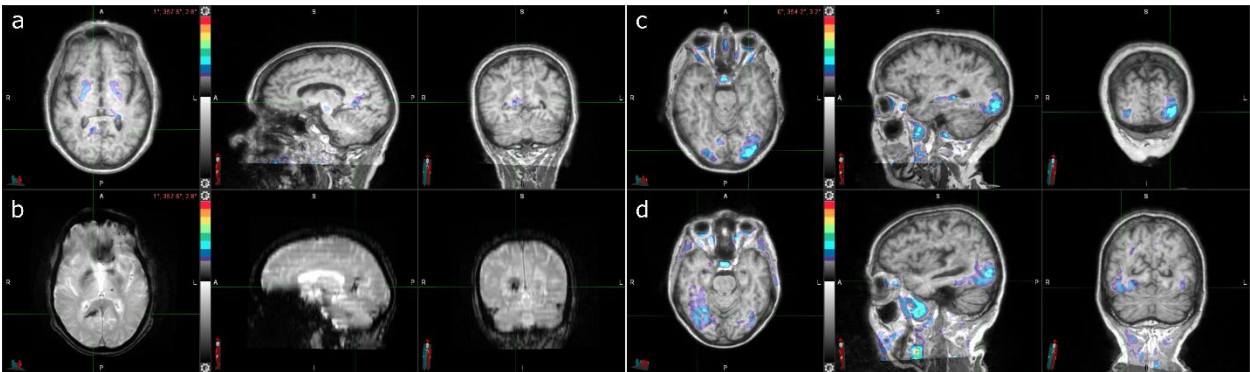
Three cases with tau-positive visual interpretations, but tau-negative SUVRs. (a) Tau PET coregistered with MRI of a male participant in his 80s with elevated right precuneus uptake. (b) Corresponding T2*-weighted MRI showing a hypointensity (indicated by the crosshair) that colocalizes with the elevated right precuneus uptake from (a). (c) Tau PET coregistered with MRI of a female participant in her 70s with elevated occipital lobe uptake, left greater than right. (d) Tau PET coregistered with MRI of a female participant in her 70s with elevated posterolateral temporal, occipital, and parietal/precuneus lobe uptake, right greater than left.
